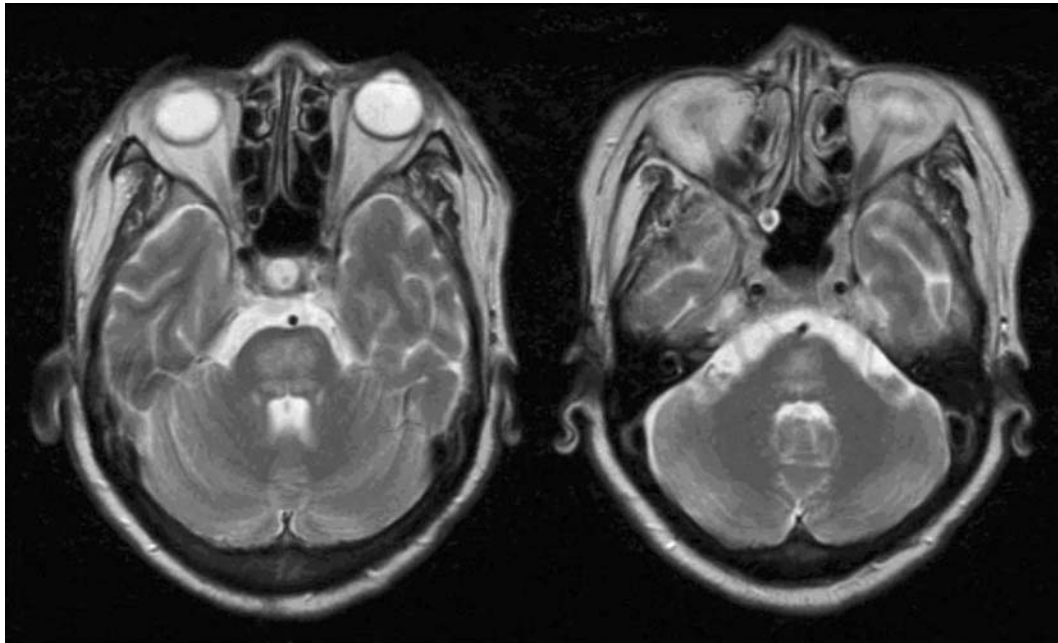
MRI T2-weighted images revealed a hypertense pontine lesion occupying mainly the basis pontis.
